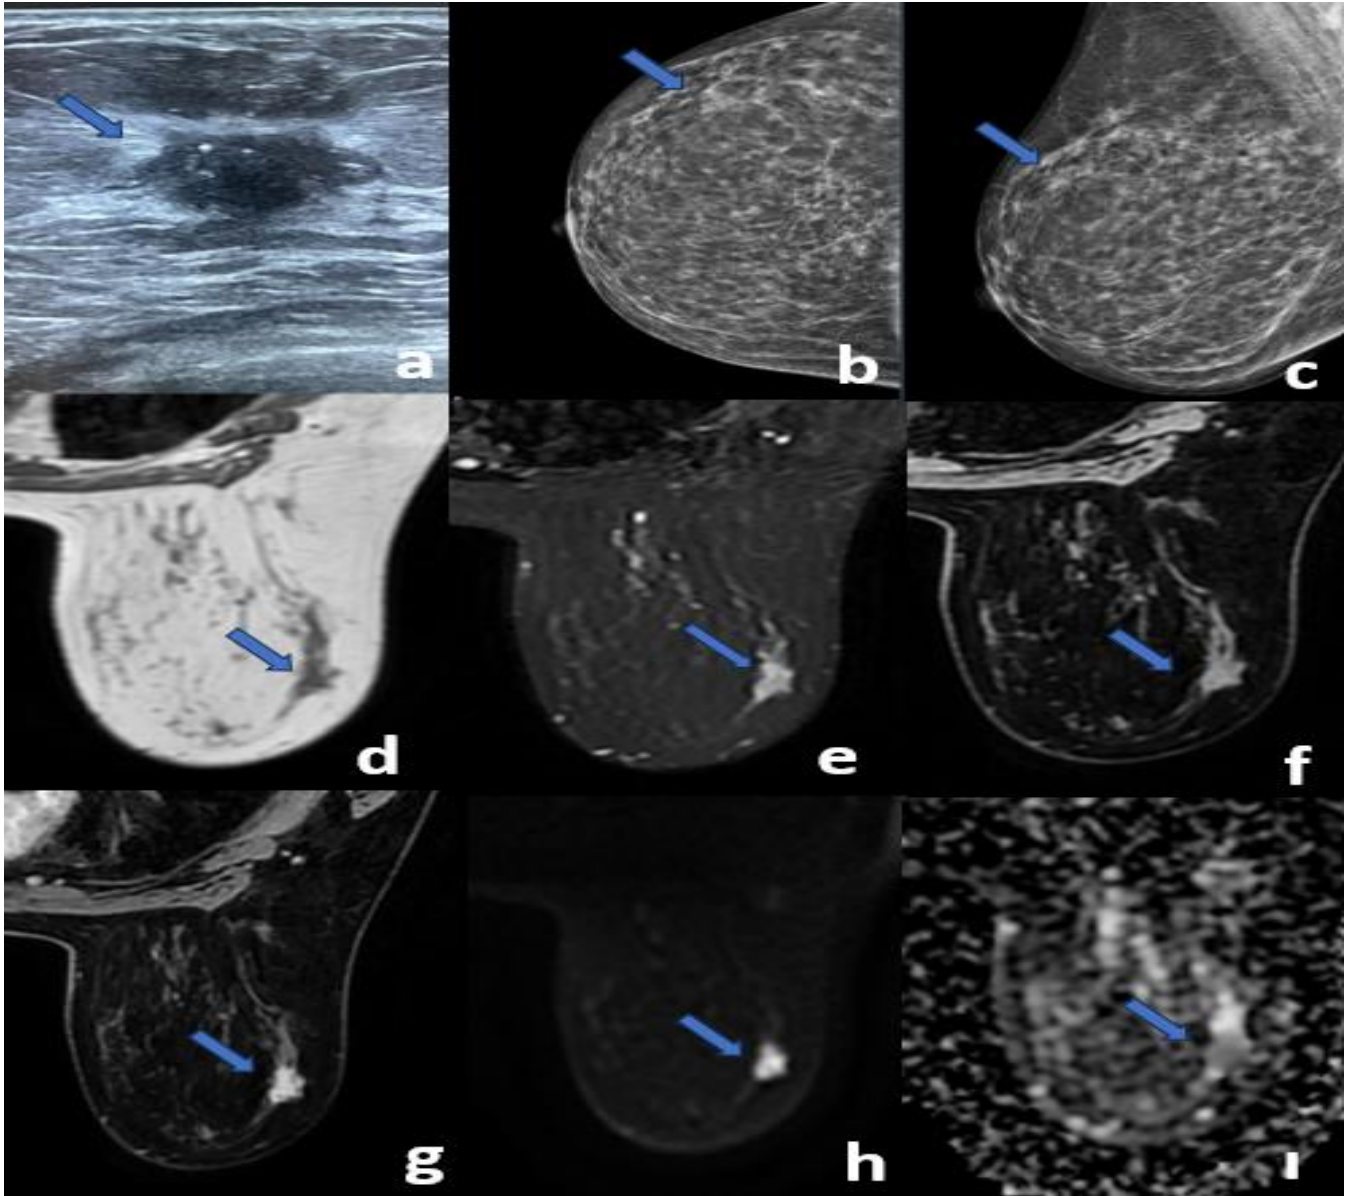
Ultrasound shows a solid, hypoechoic, irregularly circumscribed, ovoid-shaped mass (a) and asymmetric opacity on mammography (b, c). The tumor is hypointense on T1-weighted images (WI) (d), hyperintense on T2WI (e), and shows heterogeneous contrast enhancement on fat-suppressed precontrast (f) and postcontrast (g) images. Diffusion-weighted imaging demonstrates diffusion restriction (h) and ADC equivalent (i).
